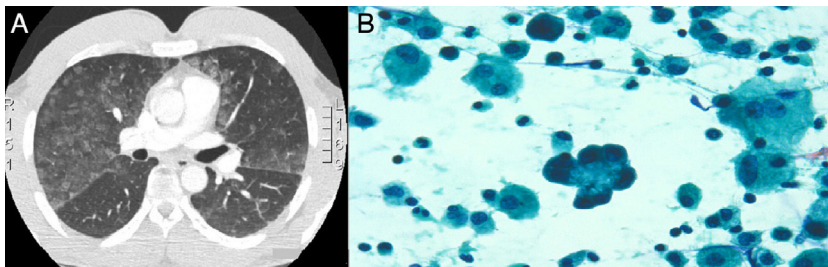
(A) CT chest: ground glass opacities of dominance lower lobes. (B) Bronchoalveolar lavage hyperplastic pneumocytes and significant eosinophilia.
